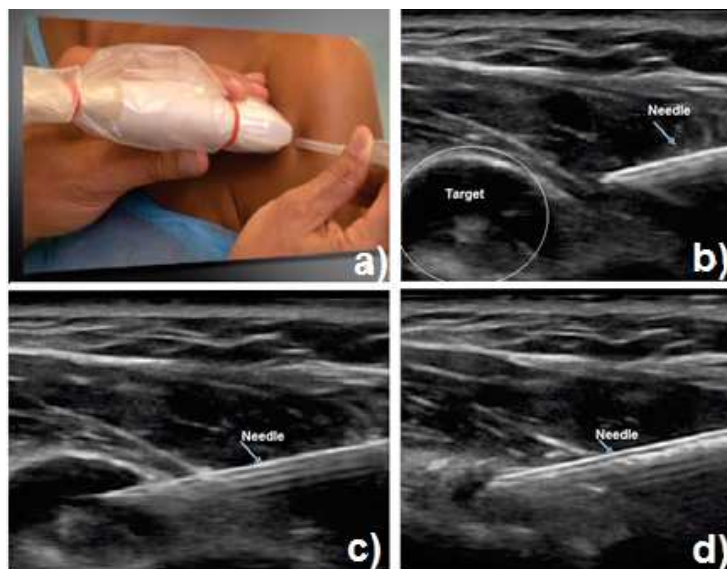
Needle advance monitoring using ultrasound-guided
